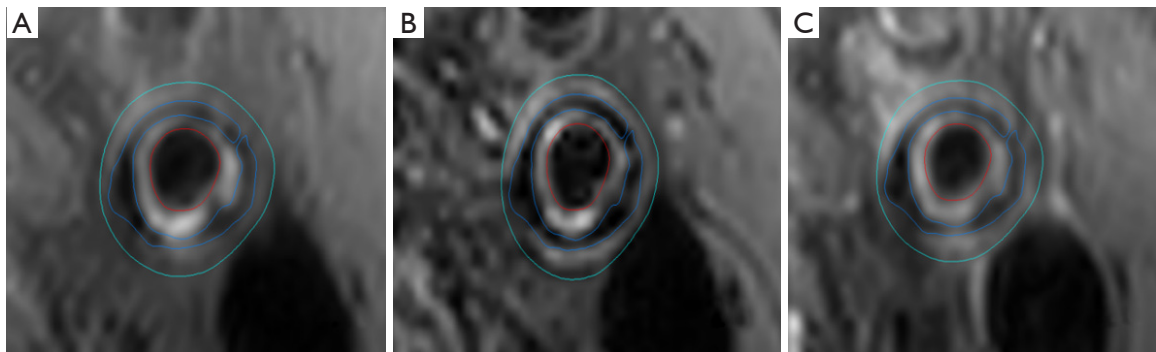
The HR-VWI images of heavy circumferential calcification of the carotid artery. Vessel walls are shown by the green lines. Vessel lumens are shown by the red lines. The presence of calcification is shown by the blue lines. Calcification shows hypointense areas on the HR-VWI images. The calcification circumference involved 4 quadrants. (A) T1-weighted imaging; (B) T2-weighted imaging; (C) post-contrast T1WI. HR-VWI, high-resolution magnetic resonance vessel wall imaging.
